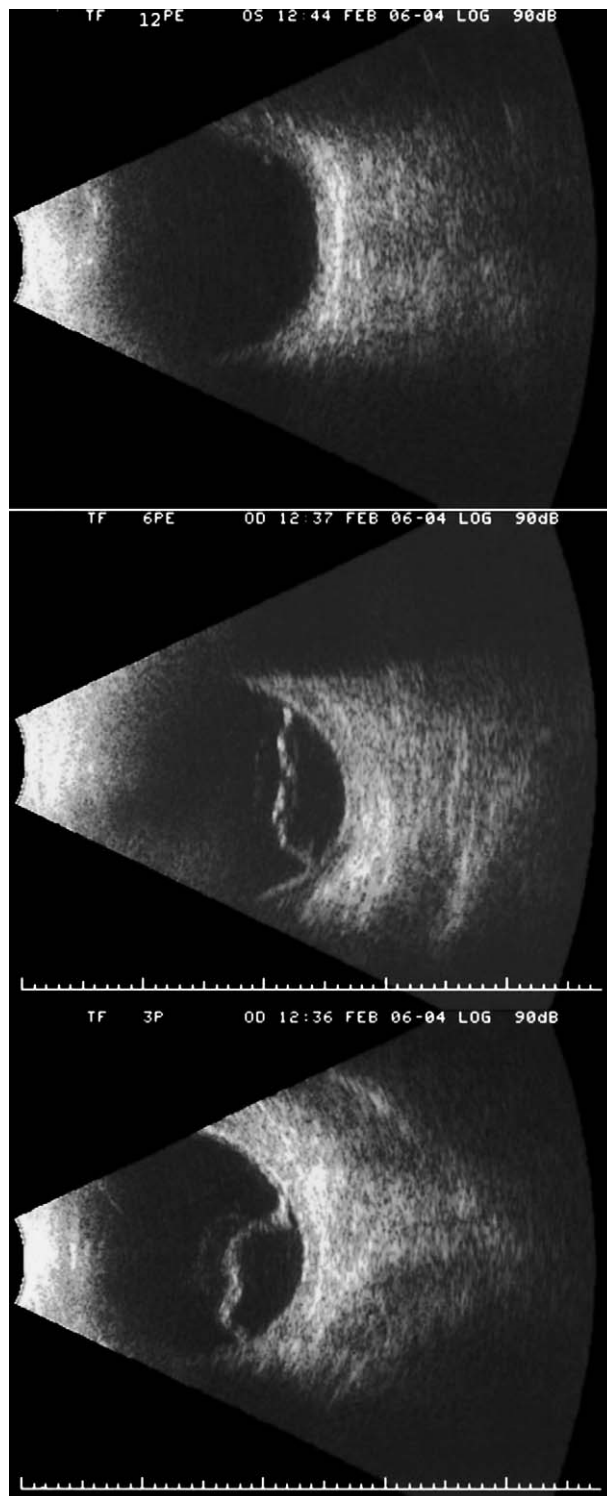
B-scan ultrasonographic image of choroidal effusion.
